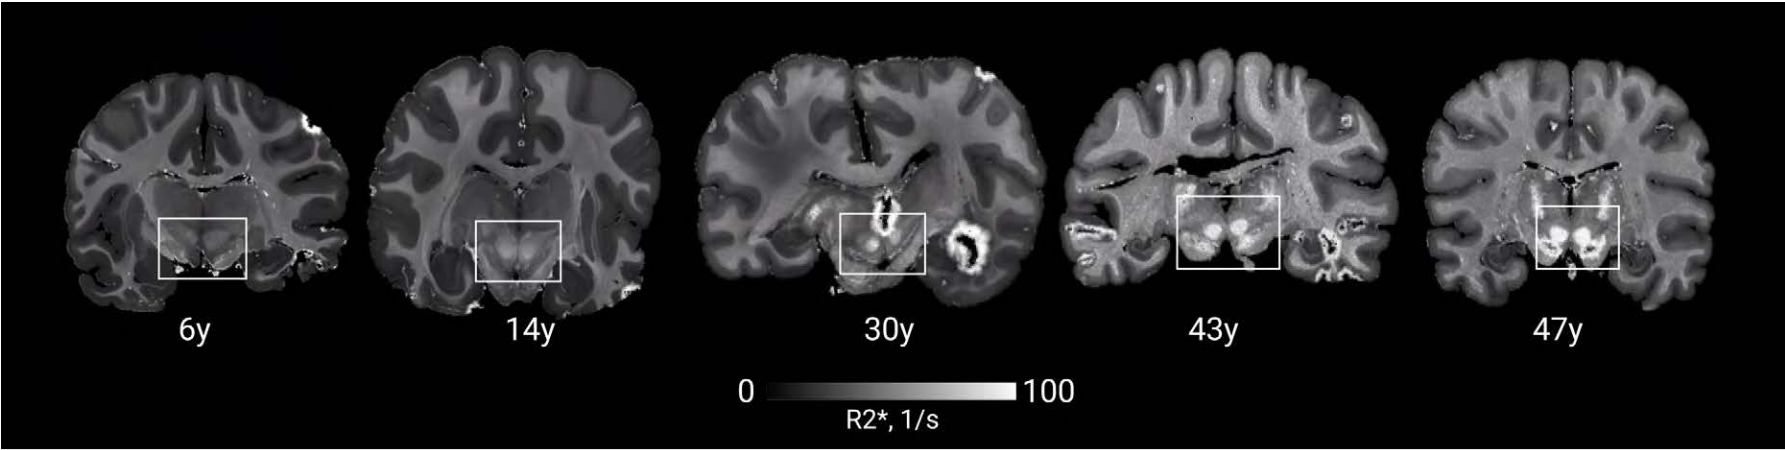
Ultra-high resolution (300µm isotropic resolution) quantitative MRI of chimpanzee brains across lifespan show age-related iron accumulation in substantia nigra and in dopaminergic neurons, reflected in increasing R2* values with age.
